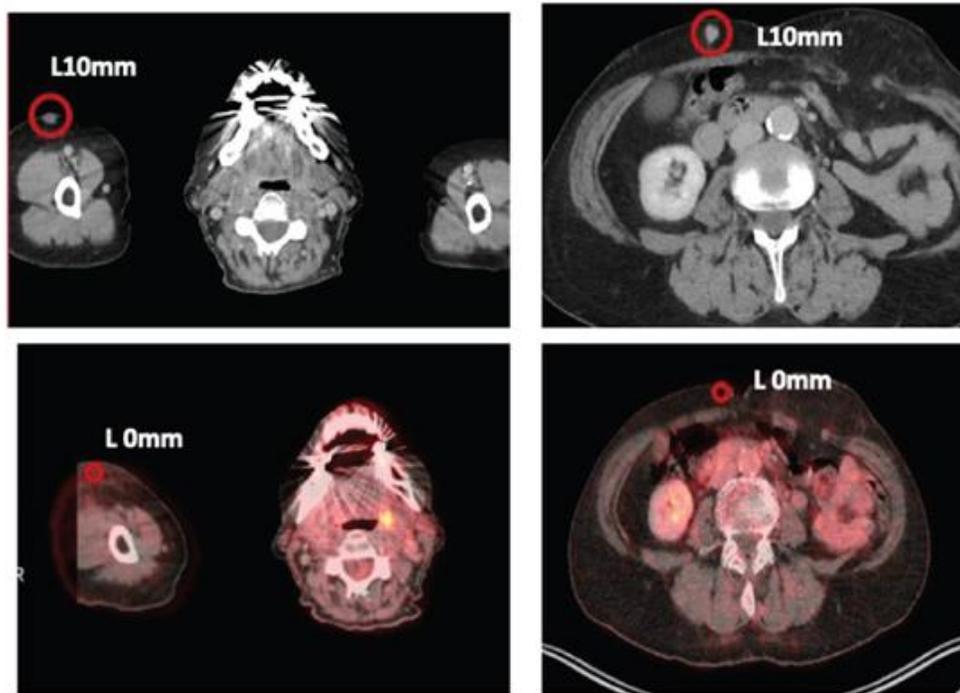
CT scan and PET-CT for Patient D02_A at enrollment (top) and following EVX-01 treatment (bottom).
